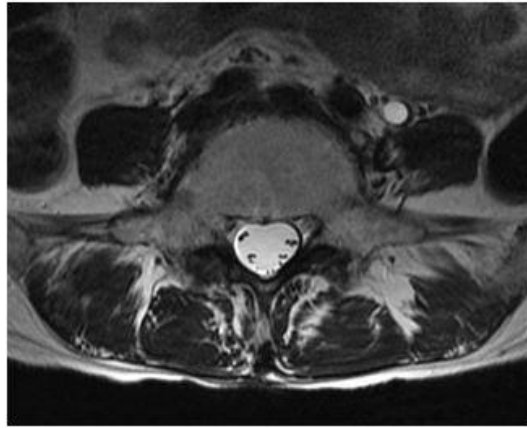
Lumbosacral T2-weighted MRI in sagittal view and axial view with bone marrow depletion and fatty changes in the vertebral bodies with subcutaneous atrophy.
